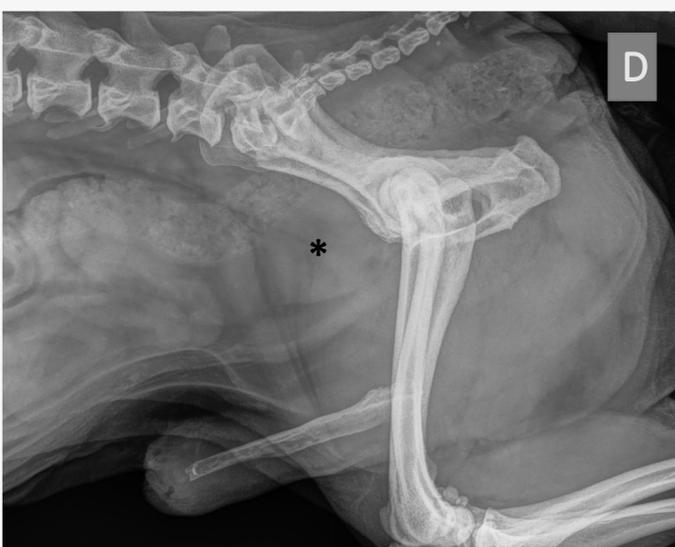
Lateral radiograph of the caudal abdomen showing prostatomegaly with dorsal displacement of the distal colon (*).
